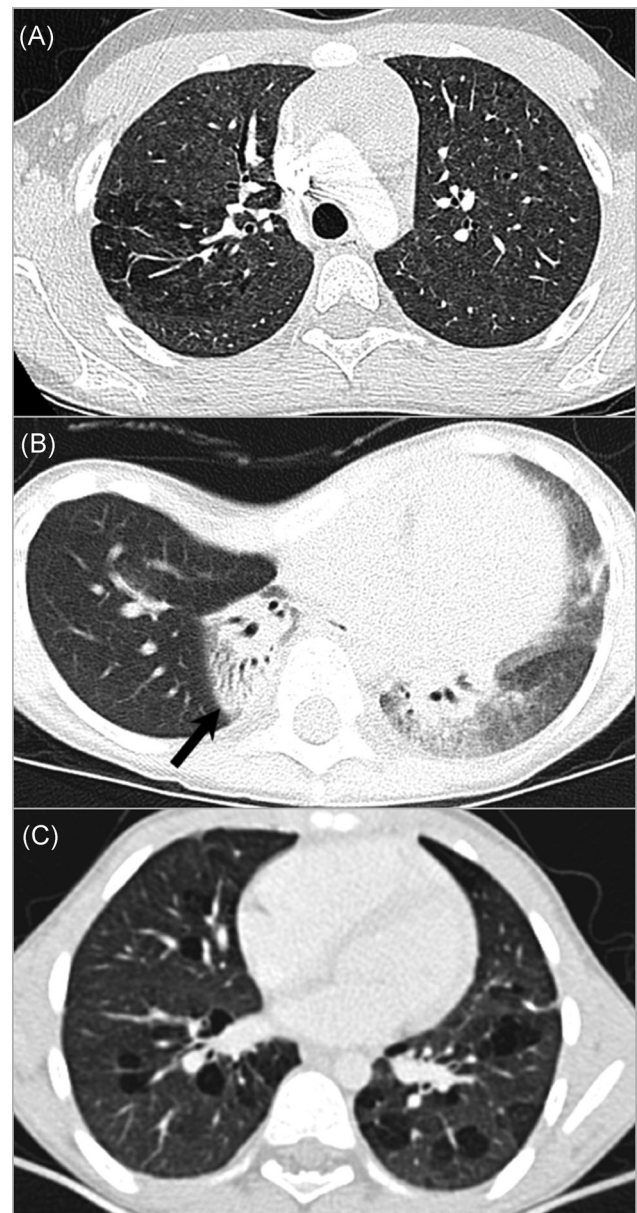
Common CT (computed tomography) findings in lymphocytic interstitial pneumonia (LIP) and follicular bronchiolitis (FB). All images were reconstructed in lung kernel with lung window settings (Width/Level 1500/−600 Hounsfield Units). A, Ground-glass opacity (GGO) in a 12-year old girl with LIP; 1.25-mm slice thickness. B, 4-year old girl with LIP/FB. Volume loss, consolidation, and traction bronchiectasis of the right lower lobe (arrow) as well as GGO on the left side are visible. Pectus excavatum; 5-mm slice thickness. C, Multiple thin-walled cysts in both lungs in an 8-year boy with FB; 2-mm slice thickness
